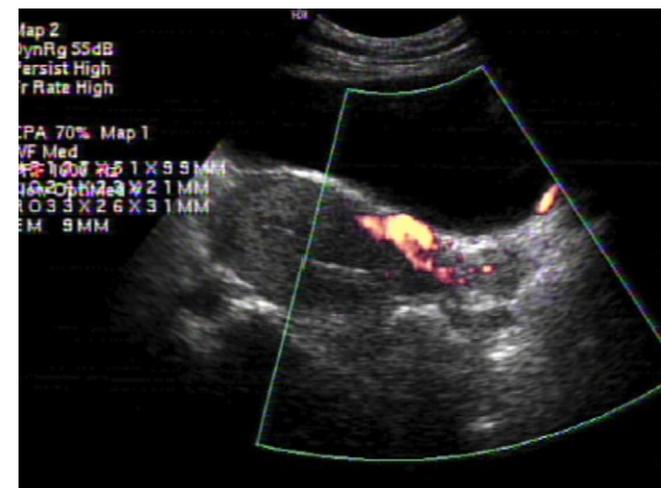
Transvaginal ultrasound reveals a significantly decreased blood flow in the uterine myometrium.
